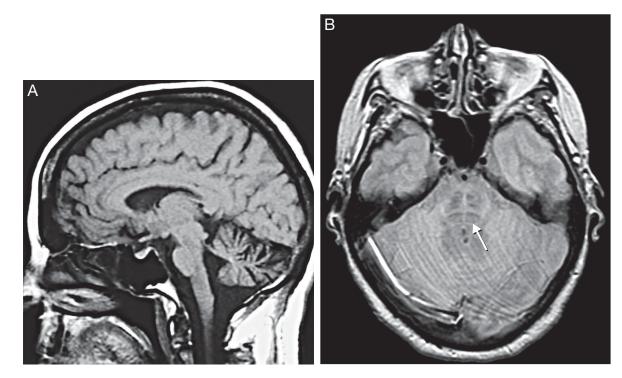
Magnetic Resonance Imaging Characteristics of Multiple System Atrophy.
